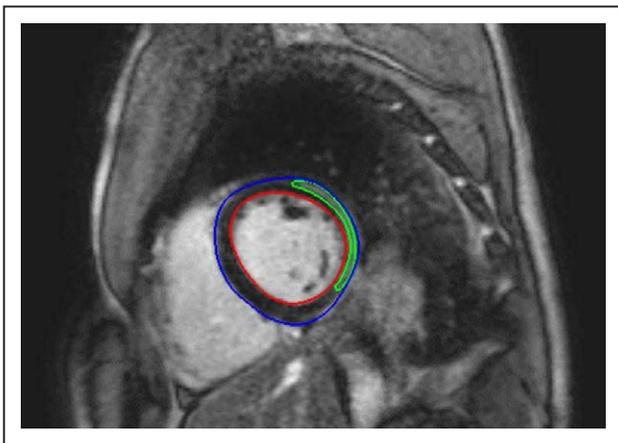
Cardiac magnetic resonance imaging of a patient with acute myocarditis, left ventricular short-axis view: Planimetry measurement in a patient with anterolateral and inferolateral late gadolinium enhancement (LGE).
